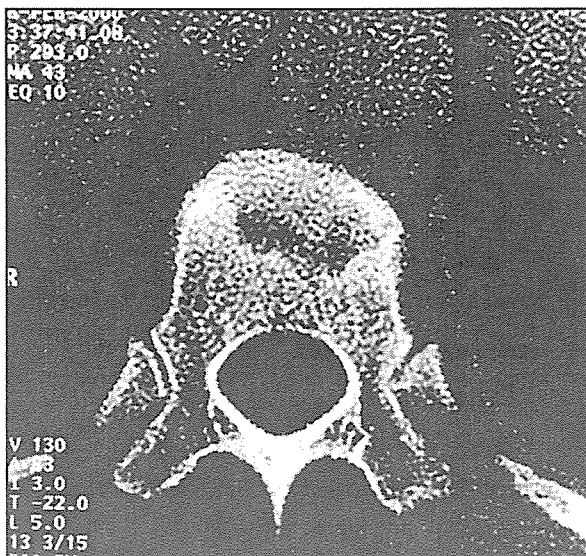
Anterior compression fracture of the T9 vertebra is detected by CT imaging. Note the minimally displaced rectangular bone fragment.
